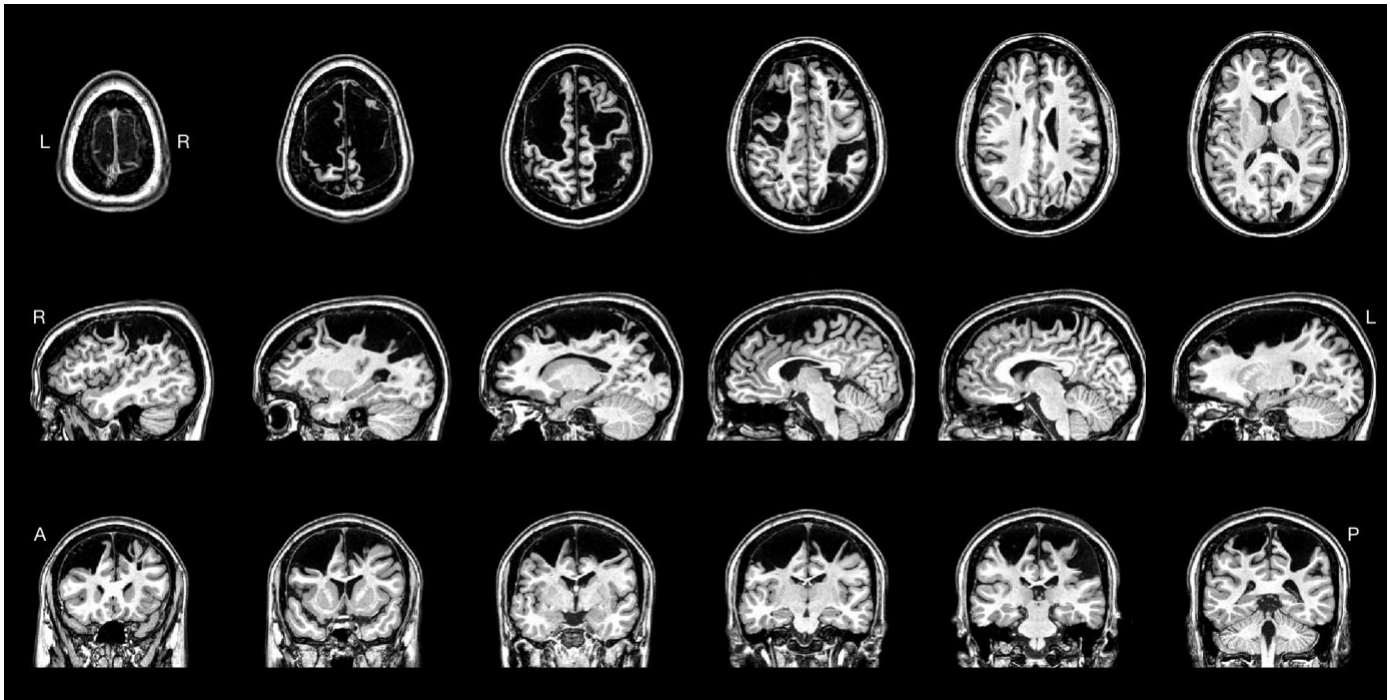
PS1's T1-weighted structural MRI (0.8 mm) demonstrates extensive bilateral tissue loss in frontal and parietal cortex.
